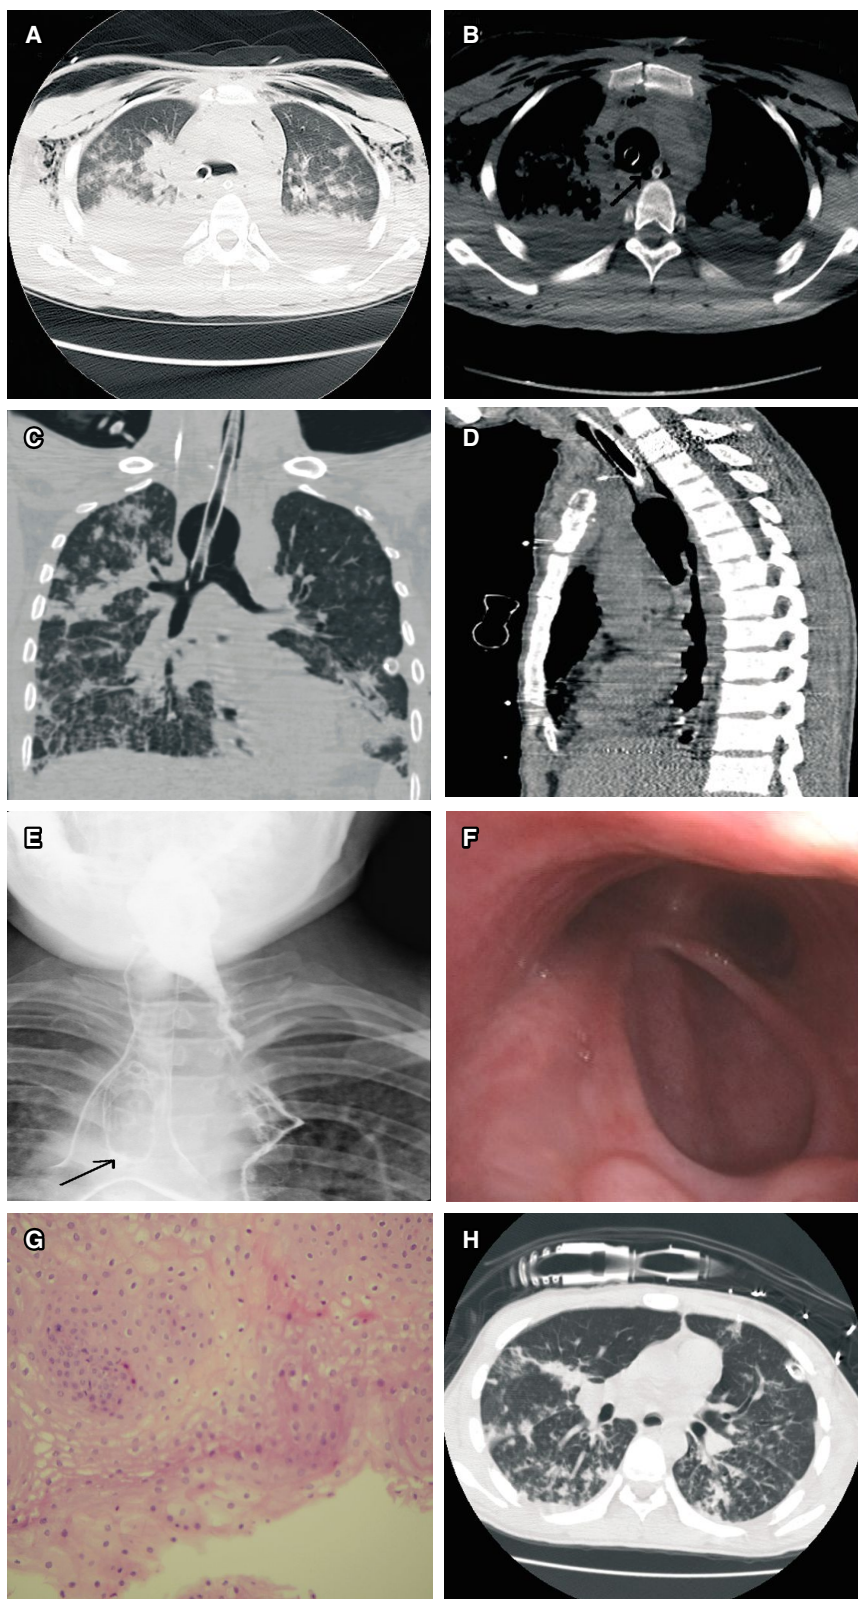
Figures of Case 1. A. Chemical burn and secondary infection in both lungs due to reflux of gastric contents; B. Computed tomogram of the thorax shows the tracheoesophageal fistula only approximately 1.0 cm (arrow); C. The intubation with left double-lumen tracheal catheter into left main bronchus; D. The cavity between esophagus and trachea was 7 cm in diameter; E. A residual cavity remains post operation; F. The residual cavity cured well after three months of operation; G. Only a few inflammatory cells founded in mucosa of the excluded esophagus; H. Lung chemical burns reduced after drainage by gastrostomy compared with the Fig A.
